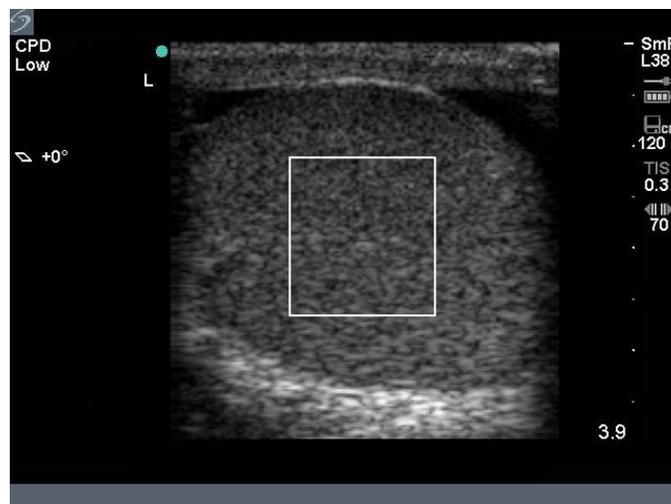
Color Doppler ultrasound (longitudinal plane, mid testis) revealing no detectable flow in the left testis.
